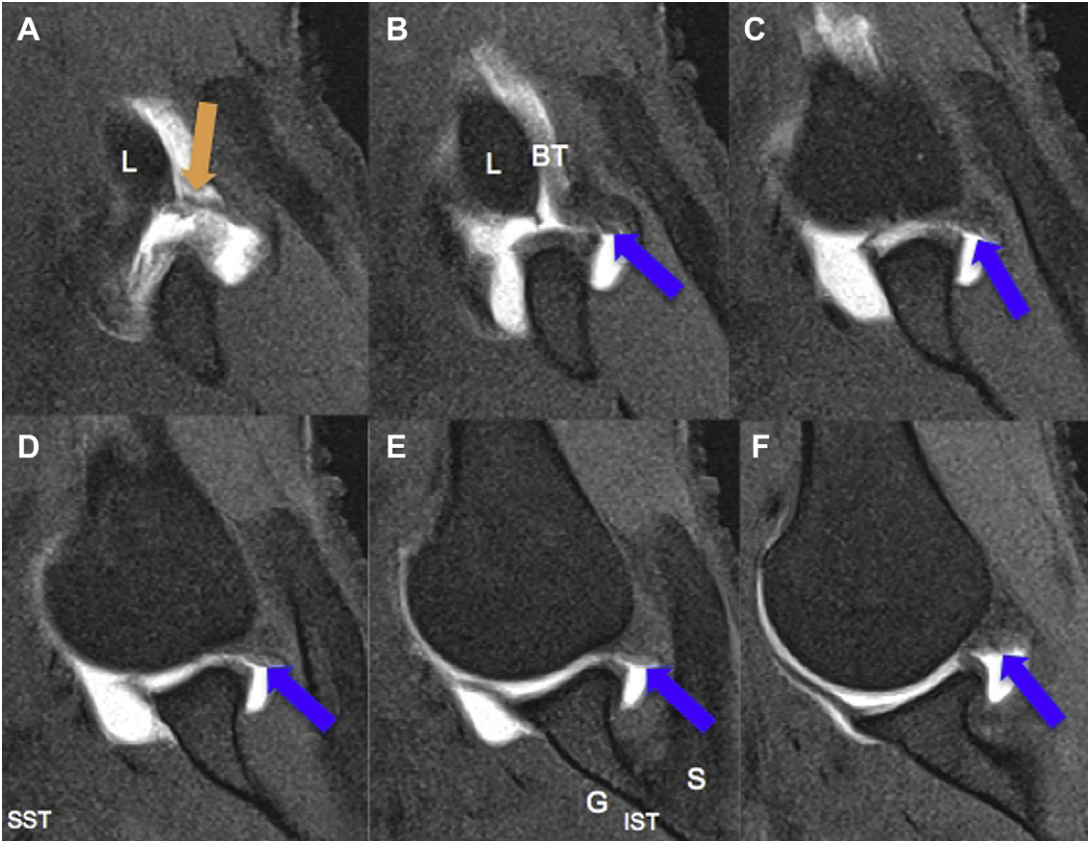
(A–F) Rotator cable (*blue arrows*) and intact cuff. Consecutive ABER fat-suppressed T1-weighted images demonstrate the superior sling of the biceps pulley comprising the coracohumeral ligament fibers (*orange arrow*) providing the roof of the biceps tendon and in continuity with the cable along the undersurface of the supraspinatus (SST) and infraspinatus (IST) tendons. BT, biceps tendon; G, greater tuberosity; L, lesser tuberosity; P, coracoid process.
